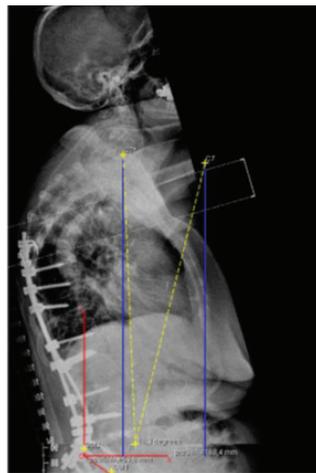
Preoperative lateral standing view X-Ray with spinal osteotomy planning.
